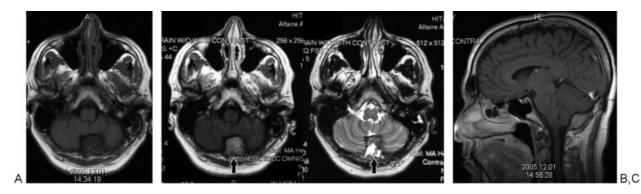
(A) Axial precontrast T1 magnetic resonance imaging showing extra-axial lesion with mild indentation of the dorsal aspect of the cerebellar vermis. (B) Axial contrasted T1 (left) and T2 (right) magnetic resonance imaging showing an extra-axial lesion with mild indentation of the dorsal aspect of the cerebellar vermis. Note the enhancement of the lesion on the left image. (C) Sagittal postcontrast magnetic resonance imaging showing moderate enhancing extra-axial lesion with mild indentation of the dorsal aspect of the cerebellar vermis.
